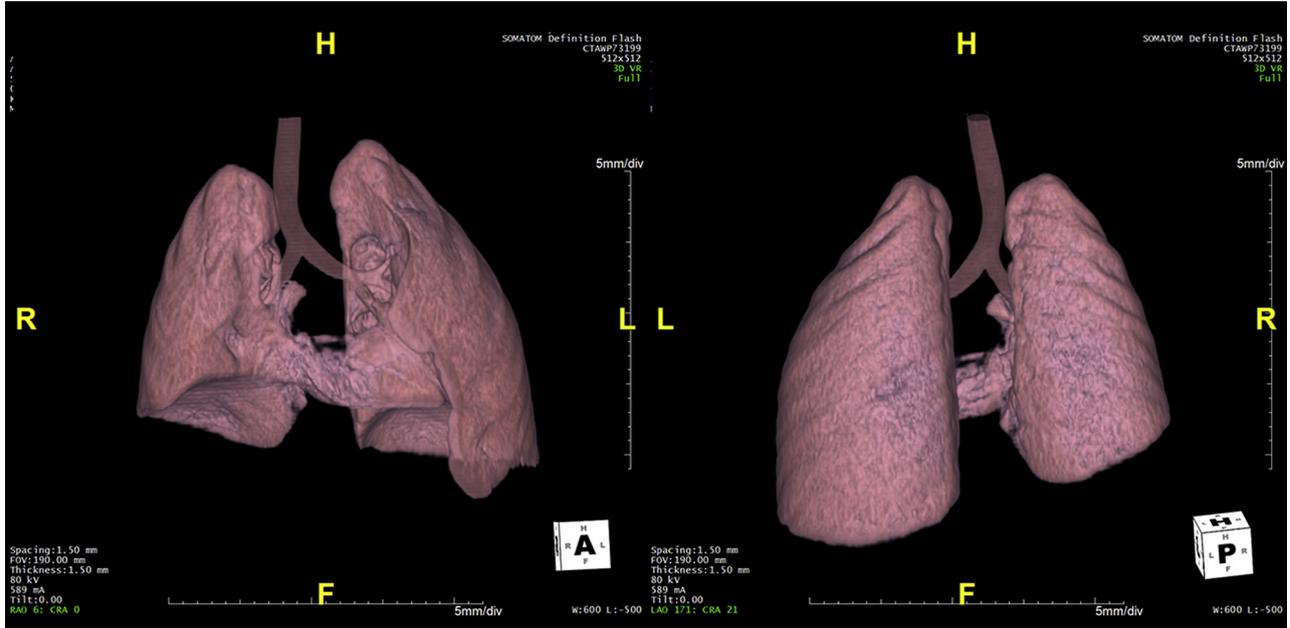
Horseshoe lung on 3D CT reconstruction images.
